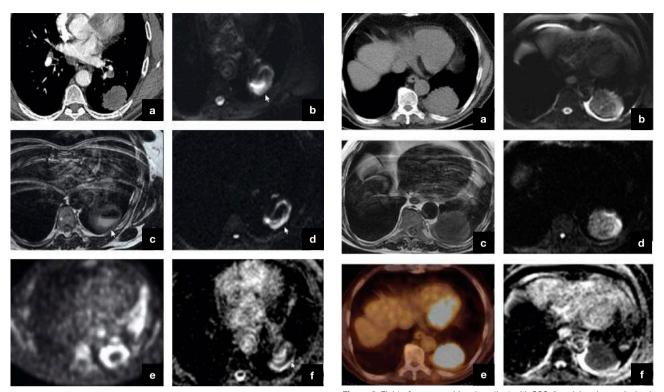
Fifty-nine years old male patient with NSCLC. The central necrotic mass lesion is located in the left lung lower lobe superior segment, peripherally. Images are from the pre-treatment period. a: Enhanced CT; b: DWI 'b value 0 s/mm²'; c: T2 weighted MRI; d: DWI 'b value 1000 s/mm²; e: PET f: ADC map.
